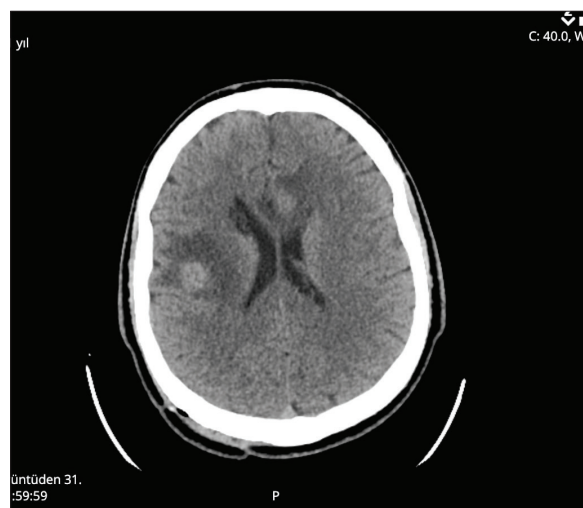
Brain CT shows a marked reduction in dilatation of the ventricular system.
